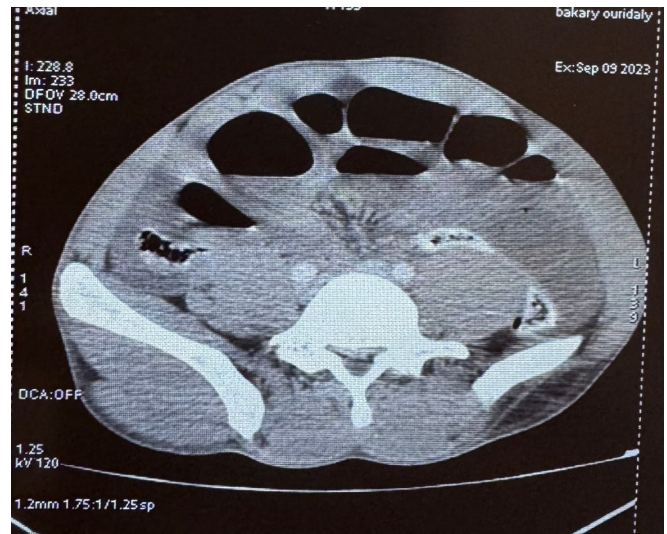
Abdominal CT scan revealing a mechanical gallbladder bowel obstruction on mesenteric volvulus.
